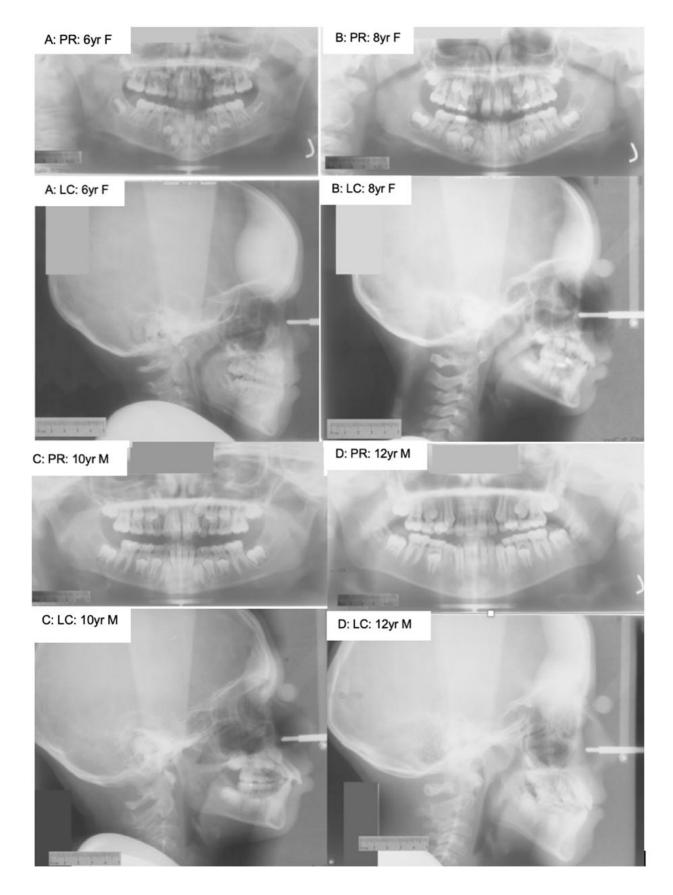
Example of PR and LC radiographs of individuals aged 6 to 12 years, *A*: *6yr F*, *B*: *8yr F*, *C*: *10yr M*, *D*: *12yr M*.
